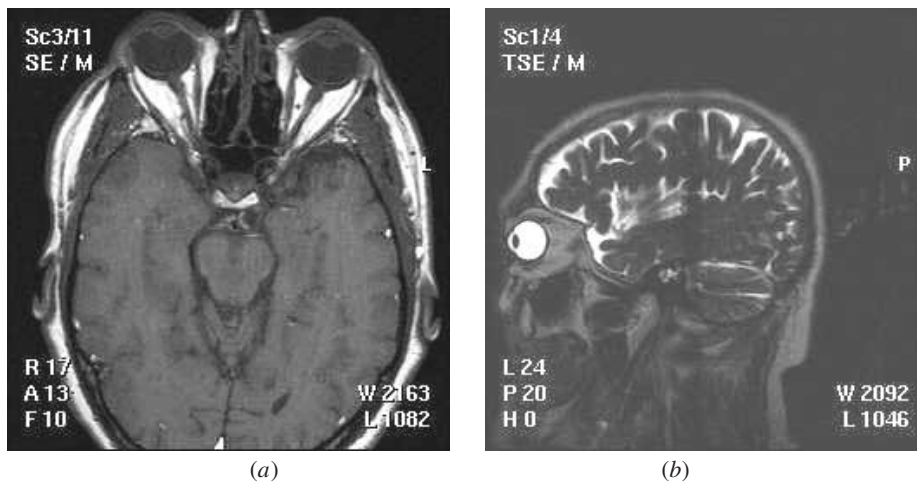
Flexibility of imaging plane and image weighting in MRI. (a) Transaxial T_1 -weighted image of the head at the level of the orbits. There is good soft tissue contrast, and fluid-filled structures, such as the eyes and the ventricles in the brain, appear dark. (b) Heavily T_2 -weighted parasagittal image of the head. Note the intense signal from CSF around the surface of the brain and from the contents of the eye, except for the dark lens (pictures courtesy of Guy's and St Thomas' NHS Trust).
